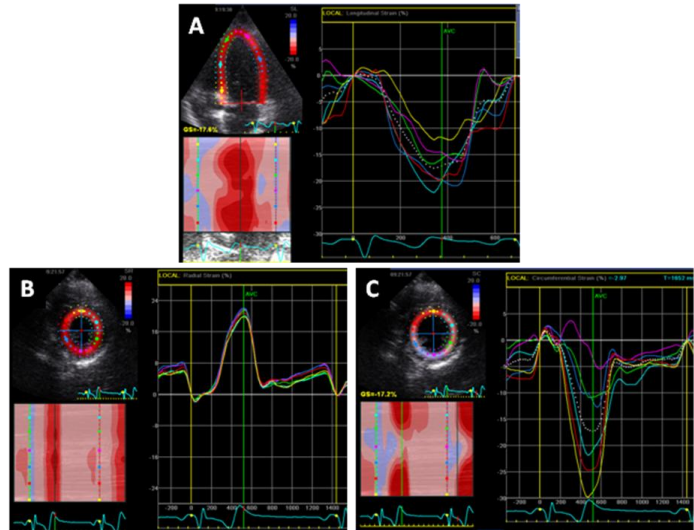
Left ventricular strain curves. A: longitudinal strain (4-chamber apical view); B: radial strain (parasternal short axis view, papillary muscle level); C: circumferential strain (parasternal short axis view, papillary muscle level)
